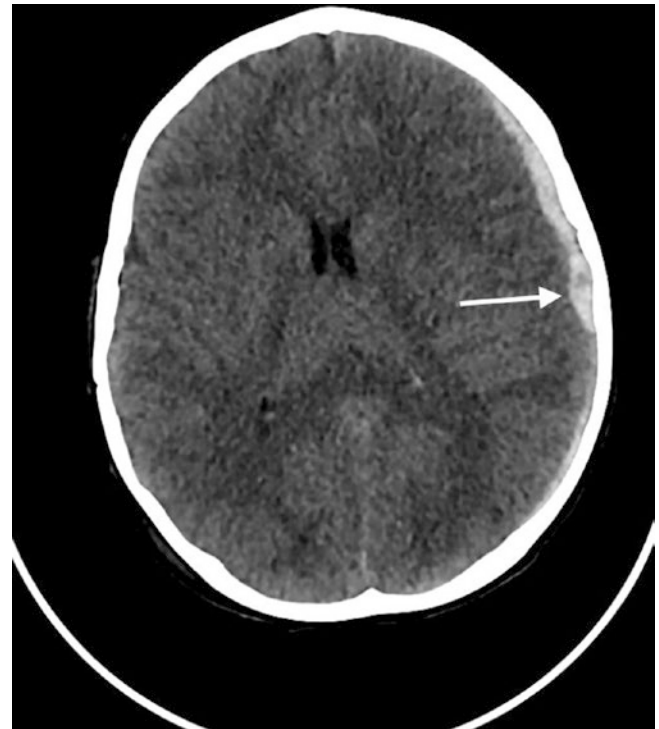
Acute subdural haematoma. Axial CT image shows a crescent-shaped area of high-density haemorrhage overlying the left cerebral hemisphere
